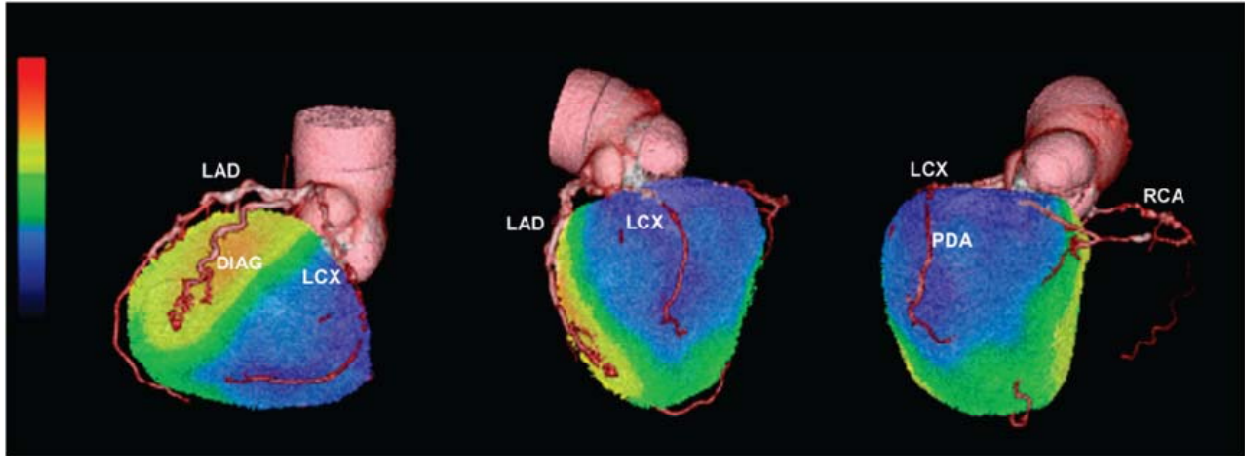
Fused 3D reconstructions of coronary CTA and stress ^{82}Rb myocardial perfusion study obtained in same setting, assessed through integrated PET/CTA. CTA demonstrated 3-vessel CAD. Fused CTA stress myocardial perfusion images demonstrate large area of severe stress-induced perfusion abnormality (deep blue color) only in territory of dominant LCX coronary artery. LAD 5 left anterior descending coronary artery; DIAG 5 diagonal artery; LCX 5 left circumflex coronary artery; RCA 5 right coronary artery; PDA 5 posterior descending artery.
